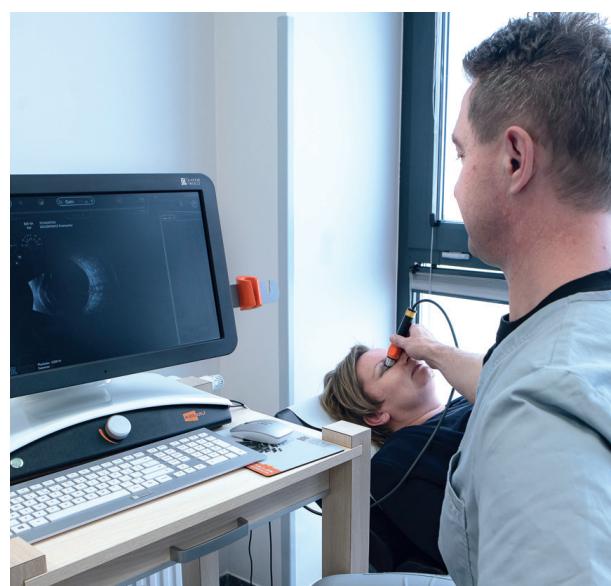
Ultrasound examination of the eyeball.
